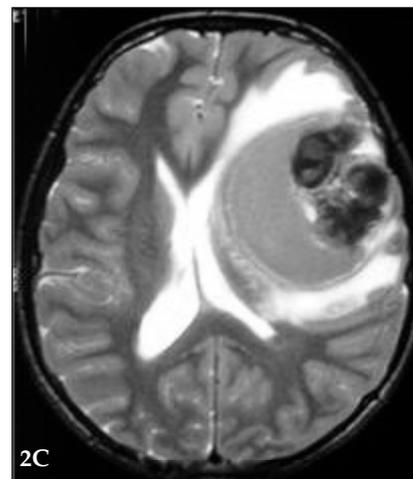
C: Axial T2-weighted image (2C) revealing low signal intensities around hypointense lesions originating from hemosiderin.
